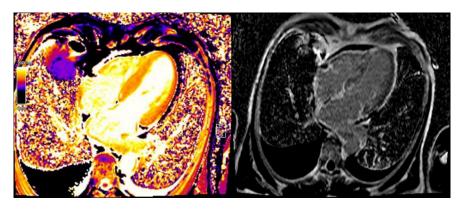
(left) Cardiac MRI showing hypertrophic cardiomyopathy and thickened interventricular septum. (right) T1 relaxation time maps. It can be seen: diffuse fibrotic tissue, pleural and pericardial effusion.
